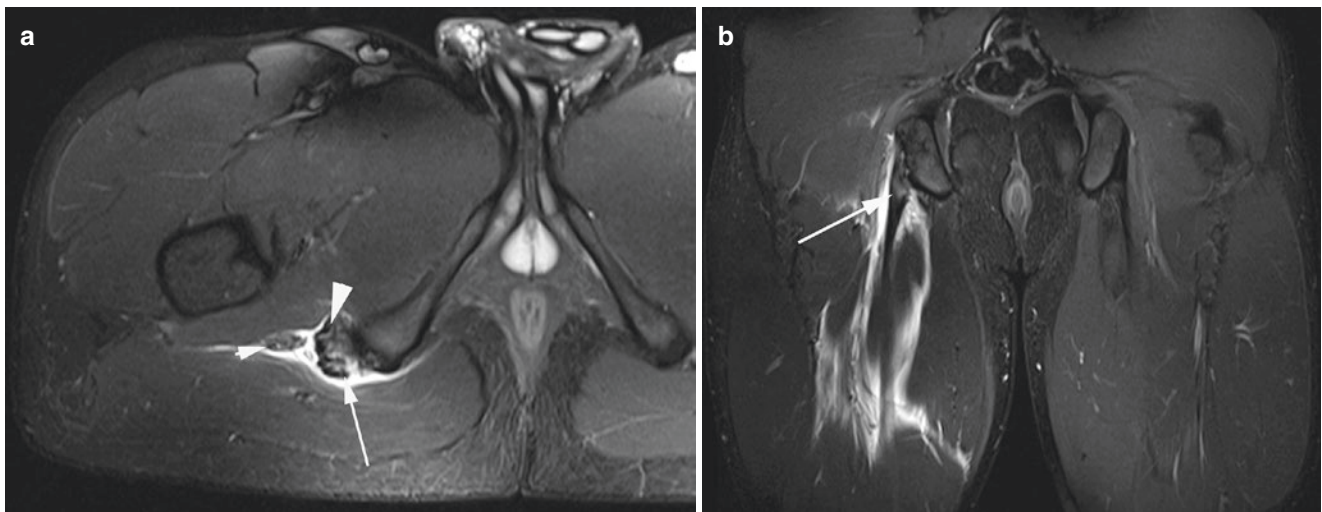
Tendon injury. A 26-year-old soccer player with acute hamstring pain. (a) Axial and (b) coronal T2FS MR images show right conjoint tendon origin partial tear (arrow), edematous but grossly intact
